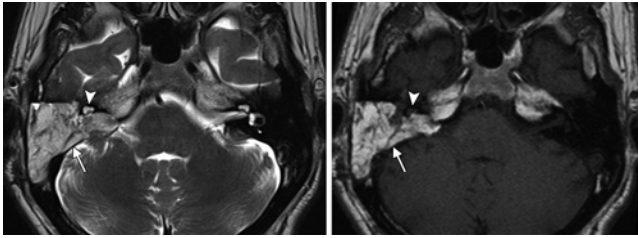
Translabyrinthine resection. Axial T1-weighted (left) and T2-weighted (right) MRI studies showing the hyperintense triangular fat graft (arrows) within the right mastoid bowl, labyrinthectomy site, and skeletonized internal auditory canal. The right cochlea remains intact (arrowheads).
